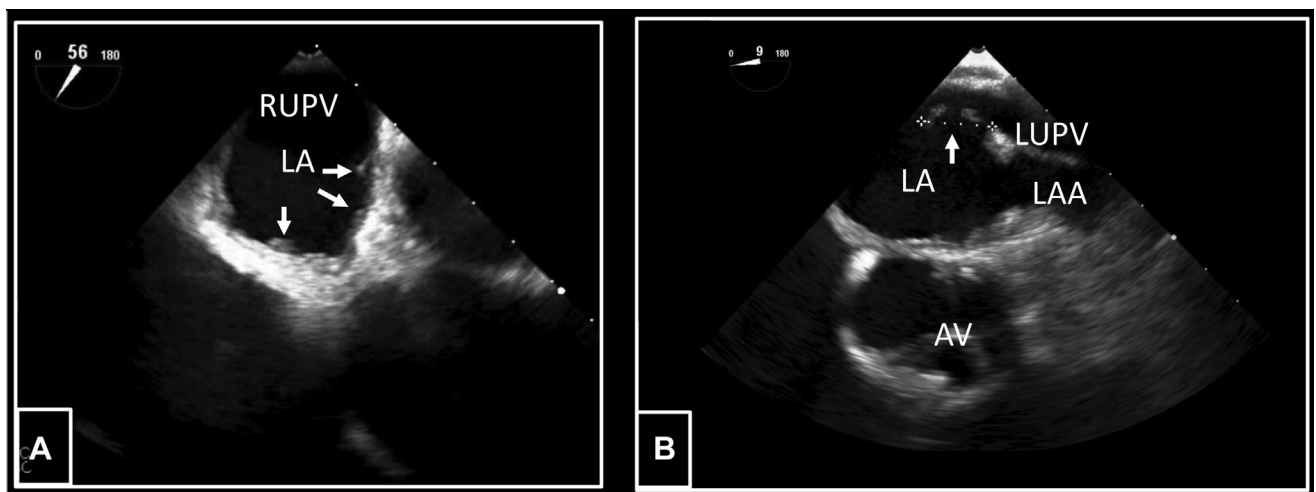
TEE-1. A: Preprocedure transesophageal echocardiography (TEE) revealed multiple, mobile elements encircling the right upper pulmonary veins (RUPV) (white arrows). B: TEE-1 demonstrating 1.5 cm filamentous thrombus anchored at the ostium of the left upper pulmonary vein (LUPV) extending into left atrium (LA). AV = aortic valve; LAA = left atrial appendage.
